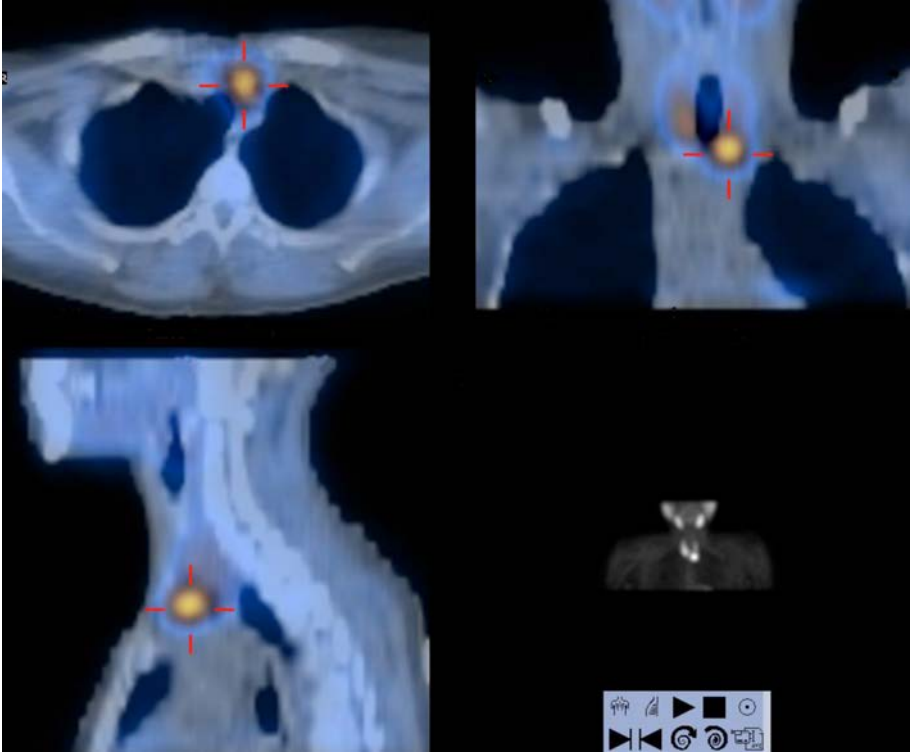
SPECT/CT images obtained of a patient with primary hyperparathyroidism approximately 2 h after intravenous administration of  $^{99m}\text{Tc}$  sestamibi. Lower right panel shows the anterior MIP of the head and chest, clearly indicating the parathyroid adenoma as an area of persistent tracer uptake located at the lower pole of the left thyroid lobe. Upper left, upper right and lower left panels show the SPECT/CT fused sections in the transaxial, coronal and sagittal planes, respectively. Both the transaxial and the coronal sections clearly demonstrate the left paraposterior tracheal localization of the parathyroid adenoma, thus providing the surgeon with useful pre-operative information for planning the most adequate approach.
